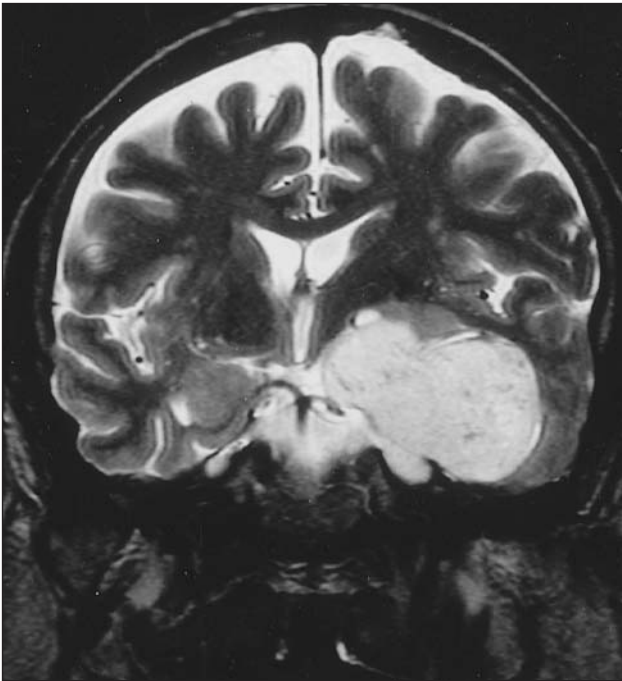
Case 1: Preoperative T2-weighted coronal MRI shows tumoral mass on the left temporal lobe related to the cavernous sinus.
